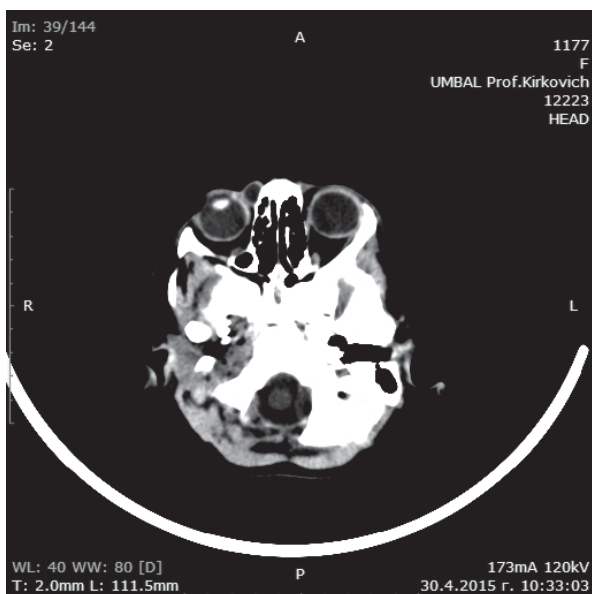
CT showing a cystic lesion in the medial part of the right orbit
